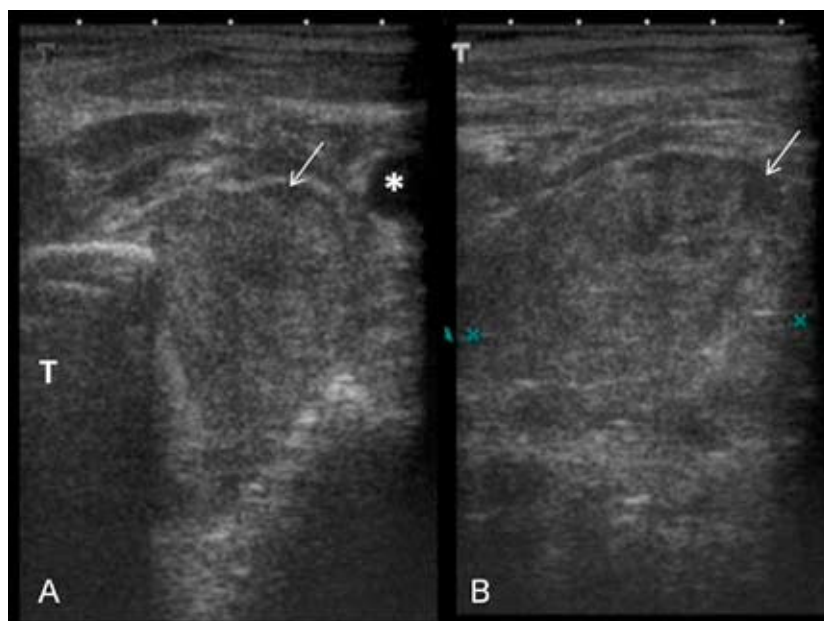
Cervical ultrasound focused on the left thyroid lobe (A and B). Enlarged glandular size with a heterogeneous mass showing hypoechoic areas in its interior and periphery (thin arrow). T indicates trachea. *Common carotid.
